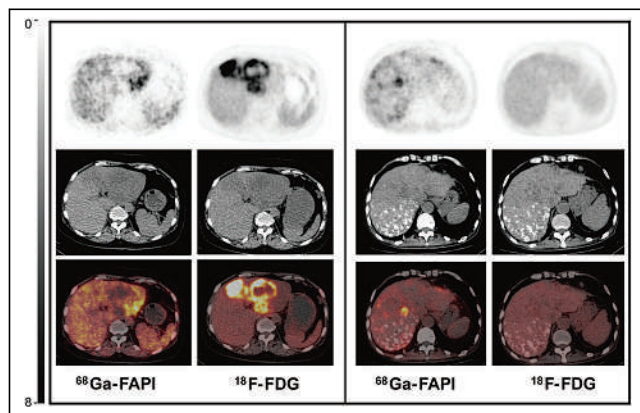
Representative baseline  $^{68}\text{Ga}$ -FAPI and  $^{18}\text{F}$ -FDG PET/CT images of patients with DCB. (A) A 63-y-old woman with multiple hepatic HCC, portal vein invasion, and lung metastases showing low  $^{68}\text{Ga}$ -FAPI avidity and high metabolic tumor burden. (B) A 47-y-old woman with right-lobe HCC, portal vein invasion, and lymph node metastases showing low  $^{68}\text{Ga}$ -FAPI avidity and metabolic tumor burden. Patients in A and B reached partial response and underwent conversion surgery. (C) A 40-y-old man with multiple intrahepatic lesions, portal vein invasion, lymph node metastases, and bone metastases. (D) A 50-y-old man with right-lobe HCC and portal vein invasion. Patients in C and D had low  $^{68}\text{Ga}$ -FAPI avidity and metabolic tumor burden, with stable disease for >6 mo. All 4 patients had OS > 12 mo. wb = whole body.
